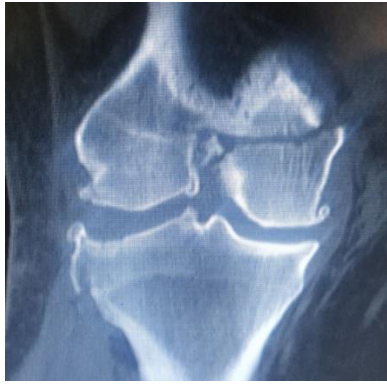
Coronal view cut of computed tomography (CT) scan showing unusual fracture pattern similar to Salter-Harris type III fracture in children
